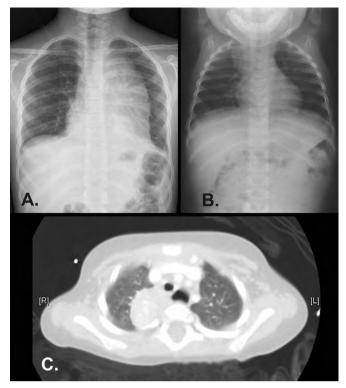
Radiographs of mediastinal neoplasms. A, Large T-cell lymphoblastic lymphoma arising from the anterior mediastinum seen on a chest radiograph in a 12-year-old. A posterior mediastinum neuroblastoma in a 3-year-old seen on a chest radiograph (B) and a computed tomography scan of the chest (C), which also demonstrates calcifications.
